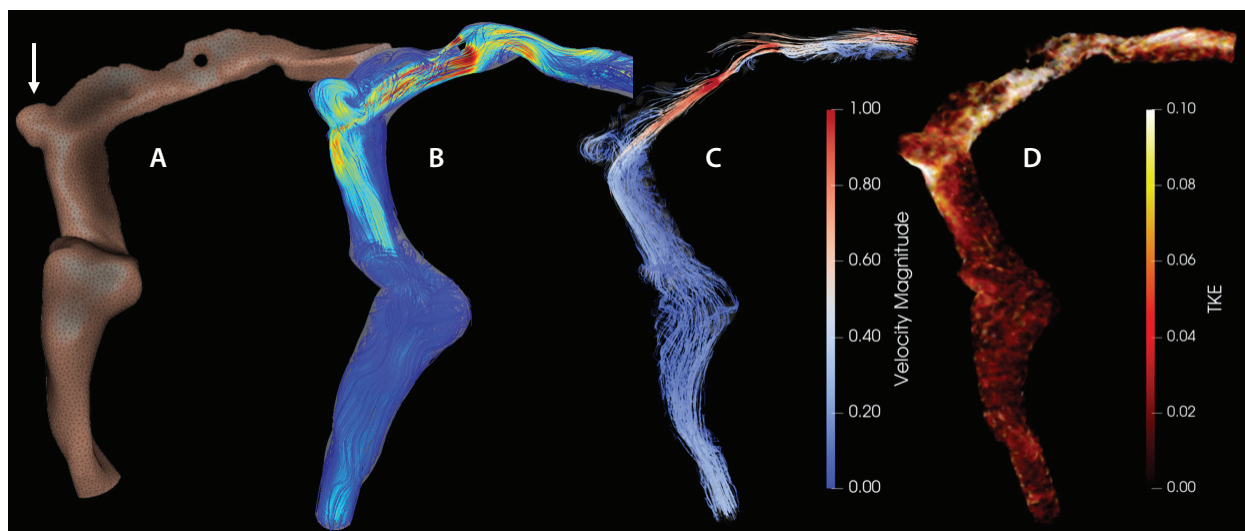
Noninvasive measurement of hemodynamics in a sigmoid sinus diverticulum assessed using four-dimensional flow MRI. Surface rendering of right sigmoid sinus with diverticulum (arrow) (A), computational fluid dynamic model (B), flow velocity profile (C), and TKE profile (D).
